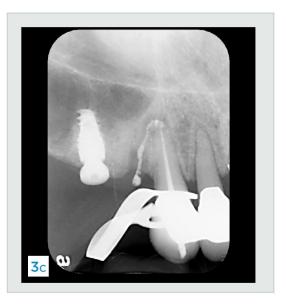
In the case of an implant lost 3 months after placement, a closely evaluated CBCT scan showed that a periapical lesion on a crowned tooth No. 6 was responsible, because initial endodontic therapy sealer followed the path of infection, thereby compromising the implant. The tooth was re-treated endodontically and allowed to heal.
